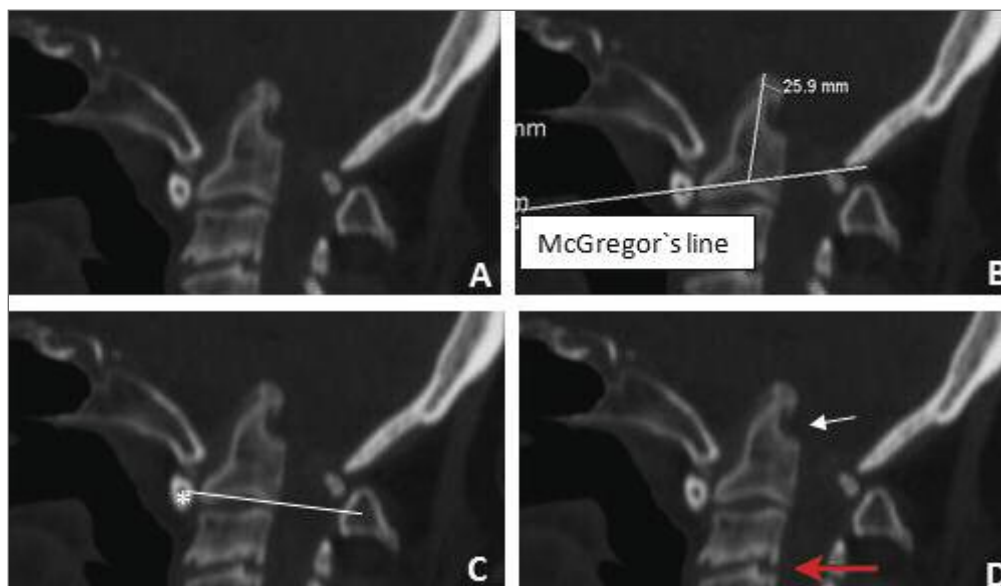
Sagittal CT reconstruction showing vertical atlanto-axial subluxation (Panel A) with migration of the tip of the dens 25.9 mm (> 4.5 mm indicates vertical subluxation) above McGregor's baseline (line between the postero-superior aspect of the hard palate and the most caudal point of the occipital curve (Panel B)); the anterior arc of the atlas (*) and the transverse axis of the atlas (white line) are at the level of C2-C3 disc, indicating severe vertical subluxation (Panel C)[†]. Note the erosion of the posterior face of the dens (white arrow) and the concomitant erosive disc changes at the C3-C4 level (red arrow) (Panel D).
